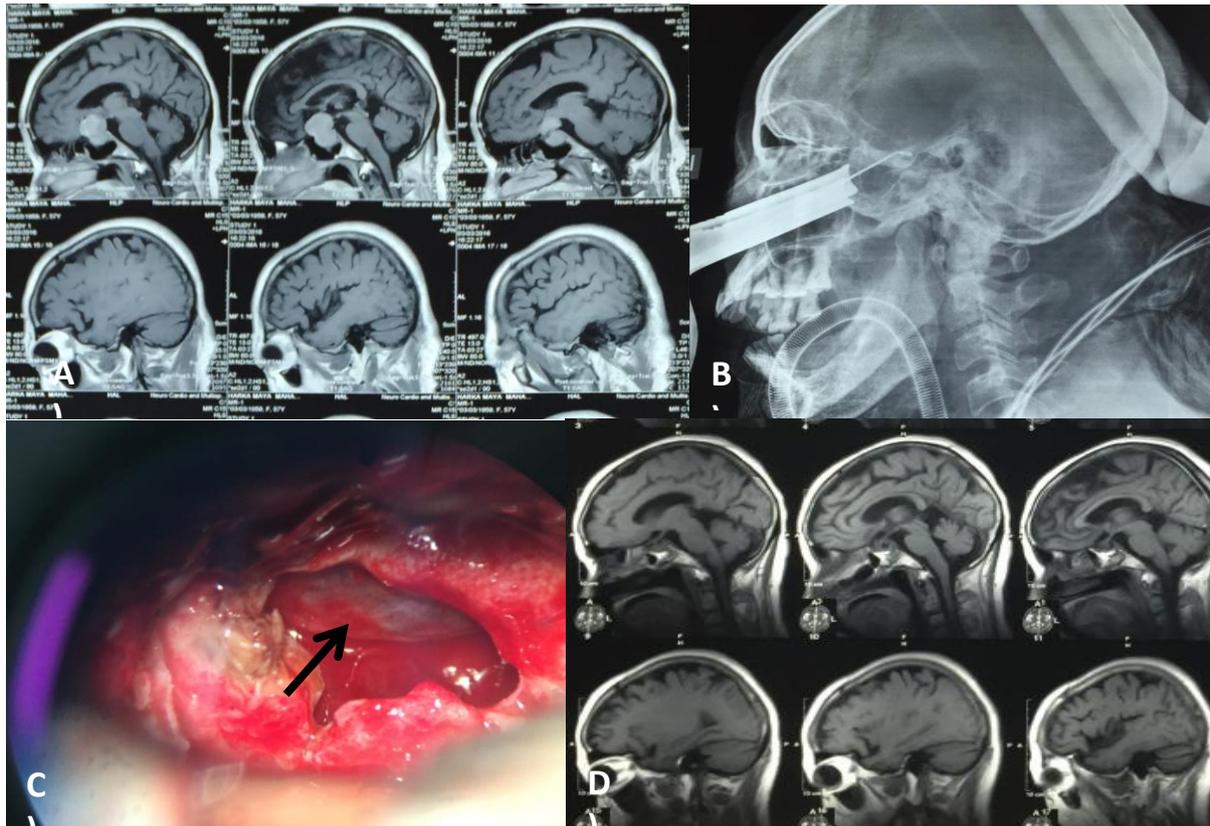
A case of pituitary adenoma, A) pre-operative MRI T1W with contrast showing pituitary adenoma, B) intra-operative X Ray showing marking of sphenoid sinus, C) intra-operative picture showing total tumor removed and diaphragm sella seen (arrow), D) post-operative MRI T1W showing complete removal of tumor
